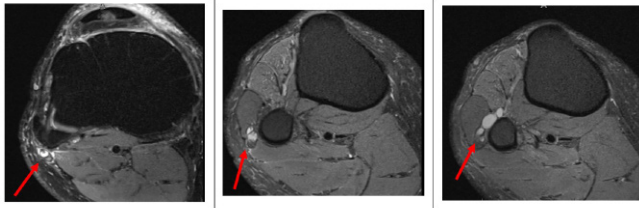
Sequential axial T2-weight MRI imaging demonstrated a cystic lesion imminating from the common peroneal nerve.
